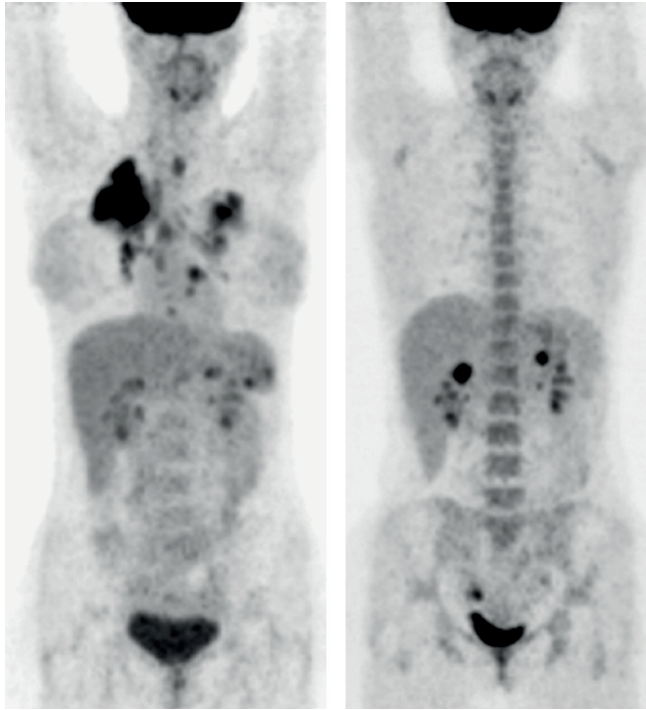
18-F-FDG-PET whole-body images. 18-F-FDG uptake in mediastinal and hilar lymph nodes and lungs (Left panel) and no abnormal 18-F-FDG accumulation after 10 months of treatment (Right panel). Adapted from (216).
